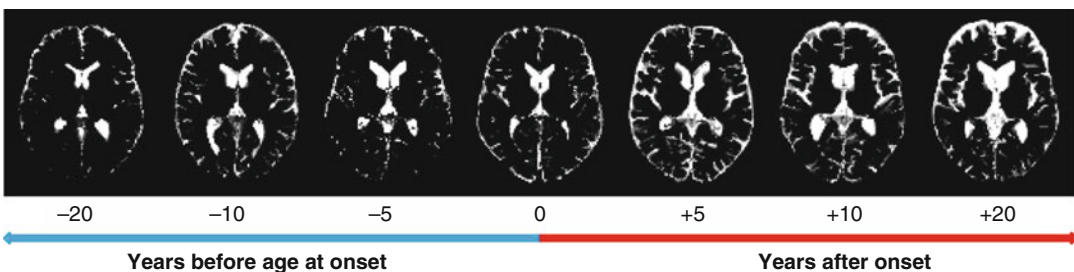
Progressive stage-dependent cerebrospinal fluid compartment increase. Axial segmented map of cerebrospinal fluid obtained from magnetic resonance imaging scan in gene-positive Huntington's disease subjects at
